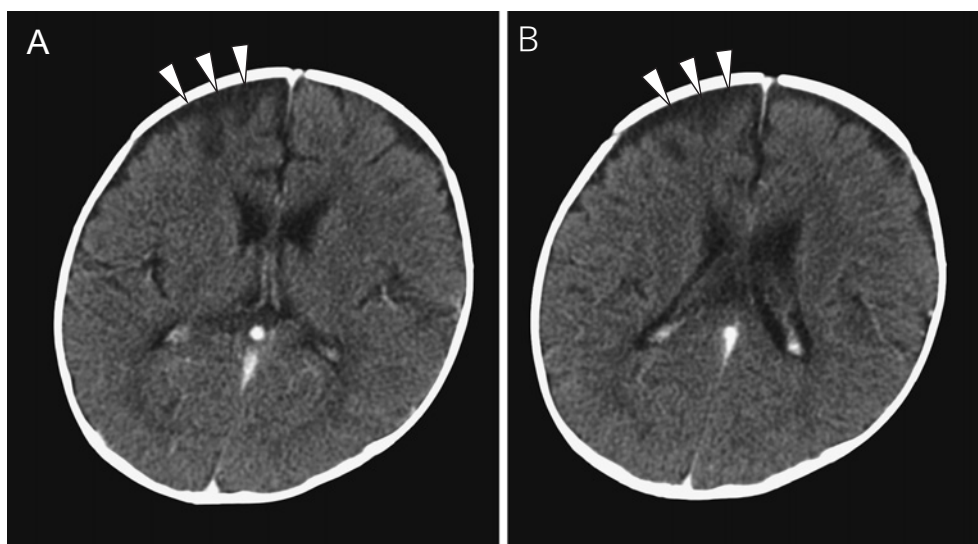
Enhanced brain CT on Day 27 (A and B).
